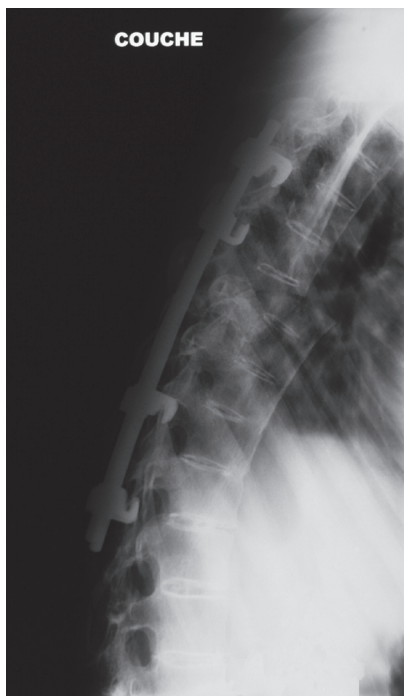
Radiography of dorso-lumbar spine after surgery.
